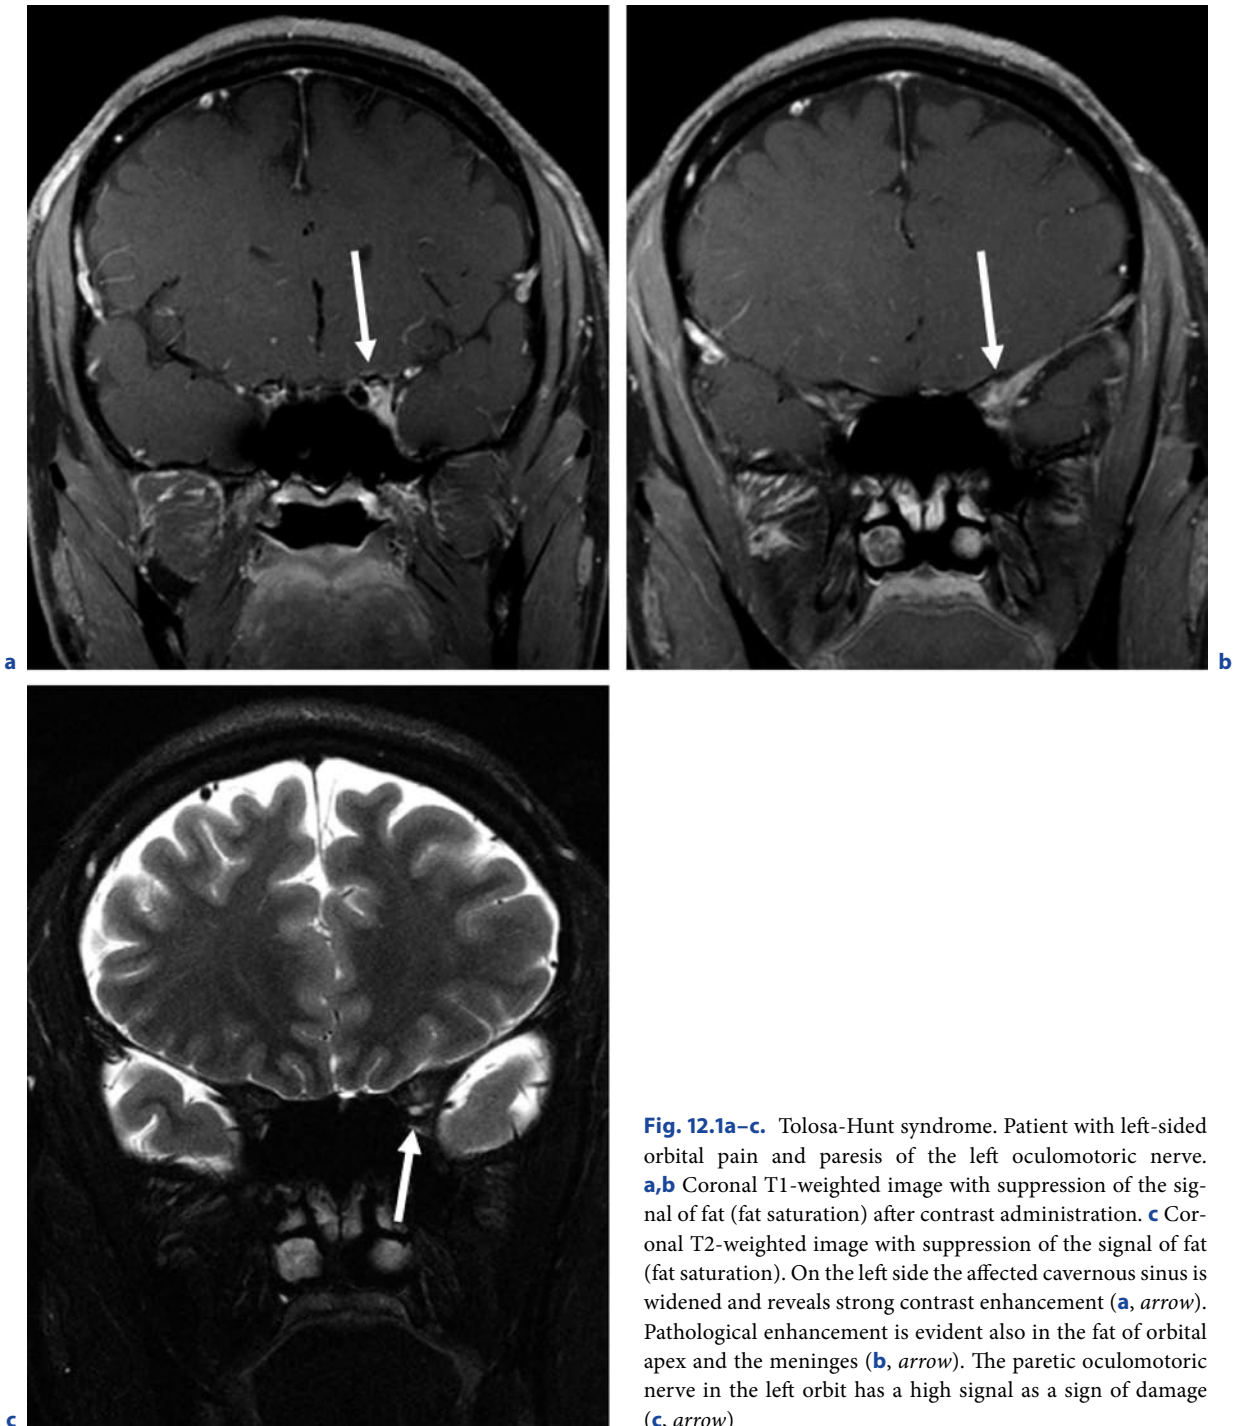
Tolosa-Hunt syndrome. Patient with left-sided orbital pain and paresis of the left oculomotoric nerve. a,b Coronal T1-weighted image with suppression of the signal of fat (fat saturation) after contrast administration. c Coronal T2-weighted image with suppression of the signal of fat (fat saturation). On the left side the affected cavernous sinus is widened and reveals strong contrast enhancement (a, arrow). Pathological enhancement is evident also in the fat of orbital apex and the meninges (b, arrow). The paretic oculomotoric nerve in the left orbit has a high signal as a sign of damage (c, arrow)
